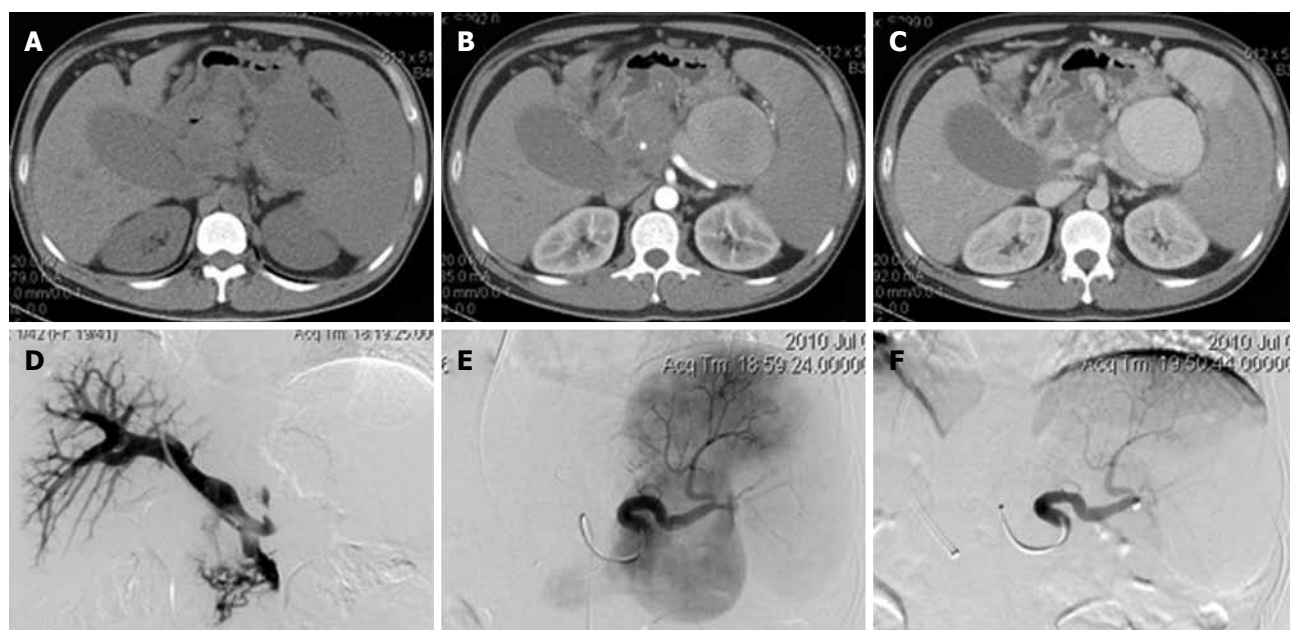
The main findings of enhanced computed tomography and angiography. A: An oval cystic low-density lesion located in the area of splenic hilum; B: The lesion was enhanced significantly on the arterial phase; C: Significantly enhanced on the portal phase of contrast-enhanced scan; D: A normal portal pressure and an increased pressure of splenic vein of 23.5 mmHg; E: Splenic arteriovenous fistula manifested by angiography; F: Splenic arteriovenous fistula being totally occluded after embolization.
